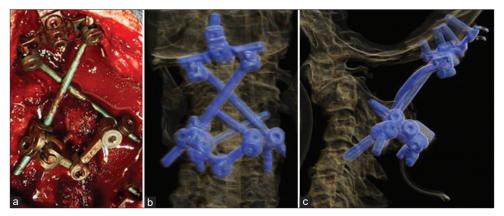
(a) Intra-operative imaging of the construct obtained. (b and c) CT scan 3D reconstructions of the patient's C-Spine and construct obtained.
